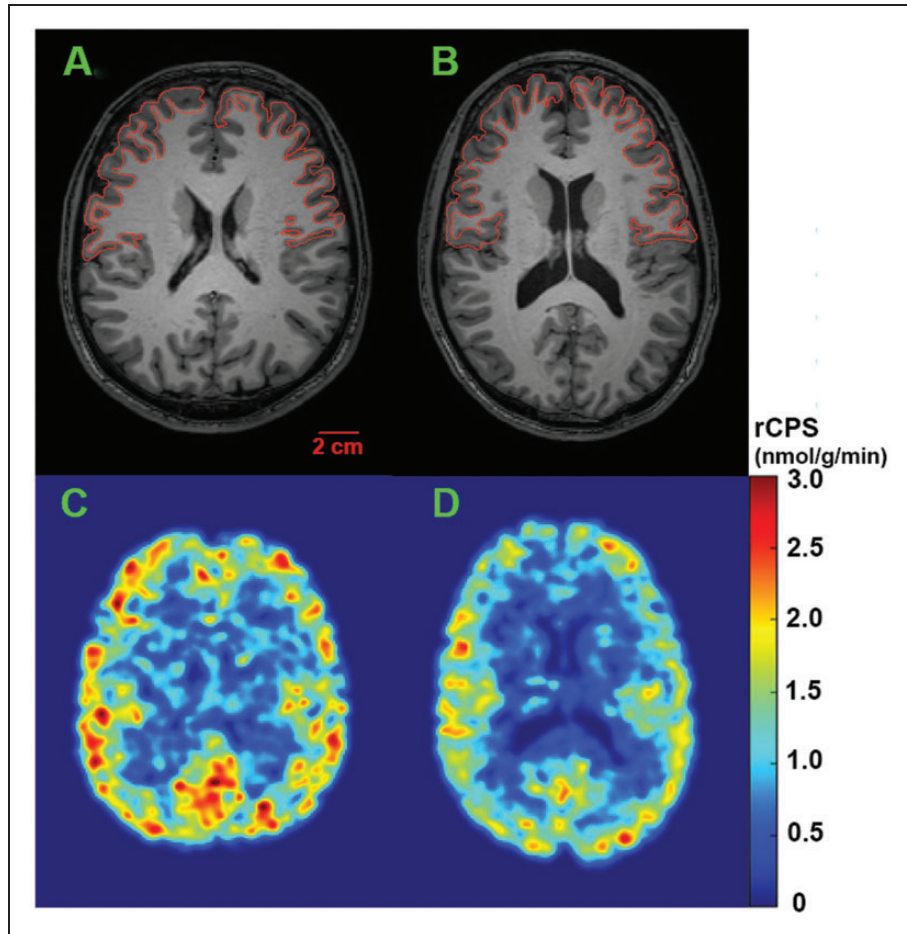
Representative parametric images of rCPS at the level of the frontal cortex in awake subjects. Magnetic resonance images (upper row) from a healthy control (A) and a subject with FXS (B) correspond to rCPS images shown below (C, D, respectively). Parametric rCPS images were smoothed with a 3D Gaussian filter (kernel 4 mm full-width-at half-maximum) and color-coded for rCPS (colorbar on the right). Images are in the transverse plane. Scalebar on lower right in A applies to all four images. We assumed a tissue density of 1.0 g/mL. Frontal cortex outlines are shown on the MR images.
